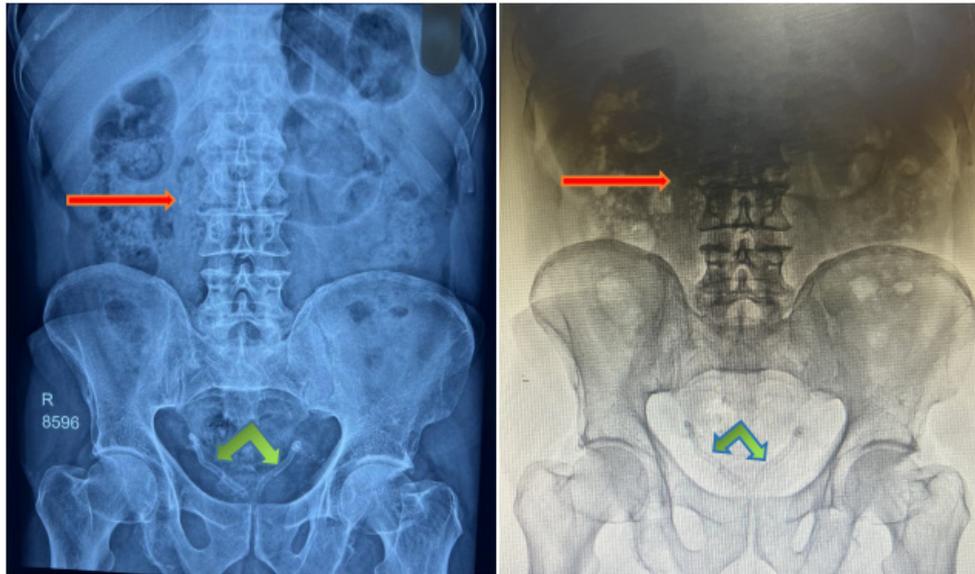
(A) X-ray KUB showing radiopaque shadow in the right upper ureteric region (red arrow) and bilateral symmetrical calcification in the pelvis (green arrow). (B) X-ray KUB with a negative image depicting the same.
